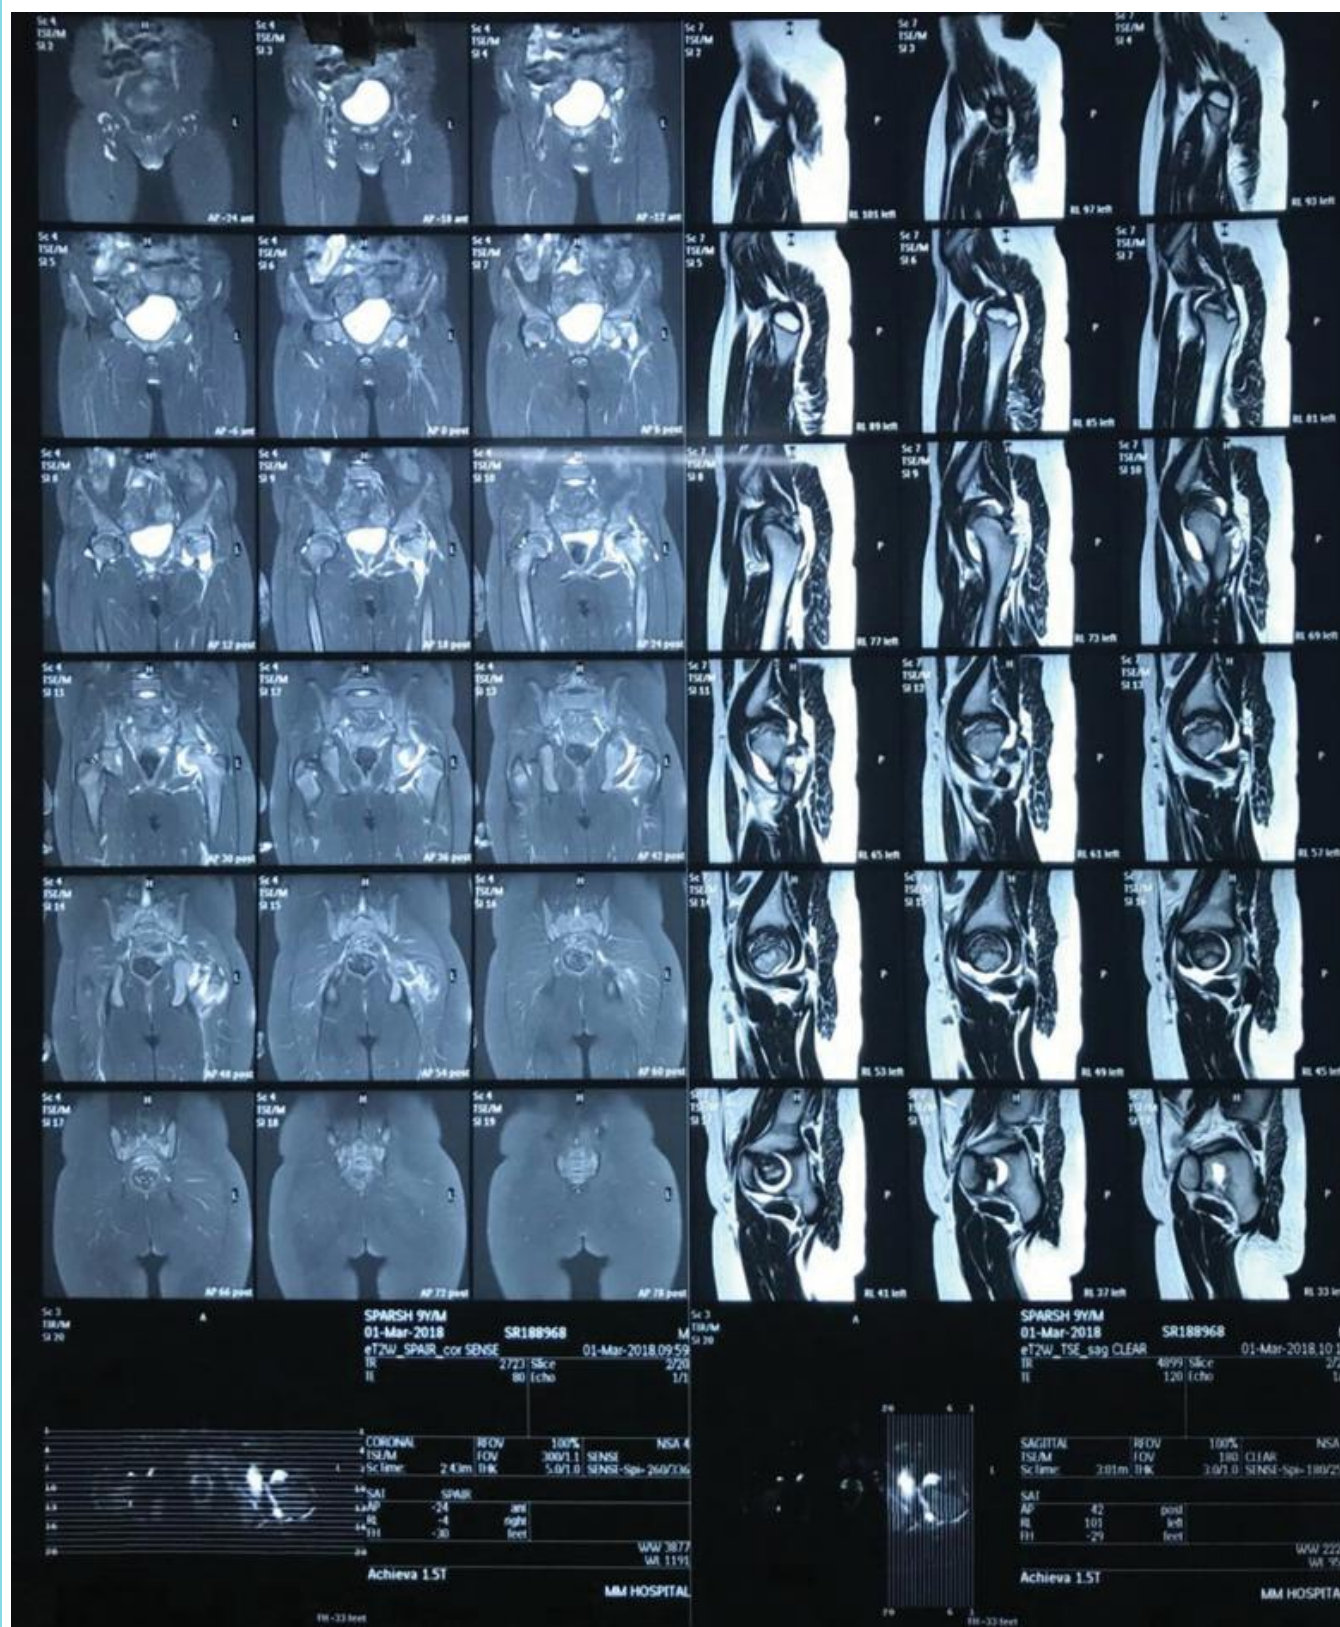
MRI of the pelvis
